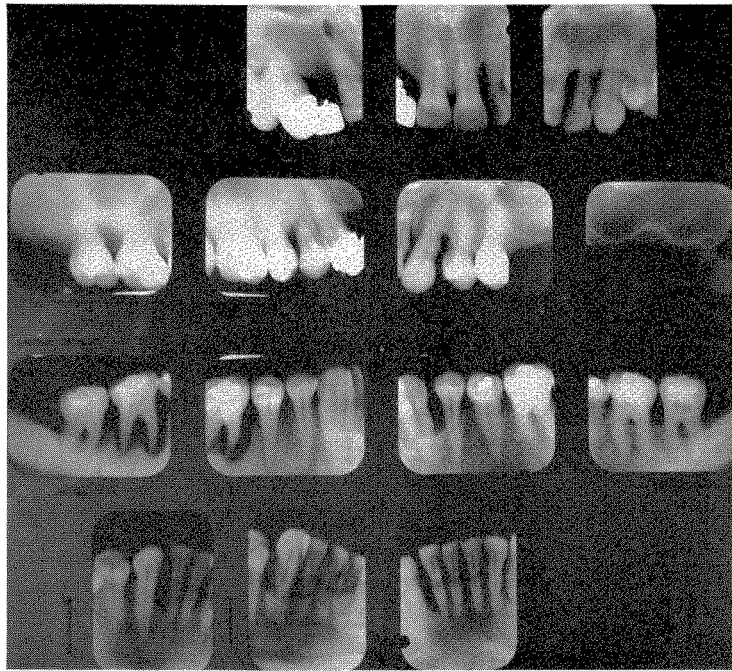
These roentgenograms were taken in 1946. They reveal the extent of the periodontal pathology before the work was undertaken.
